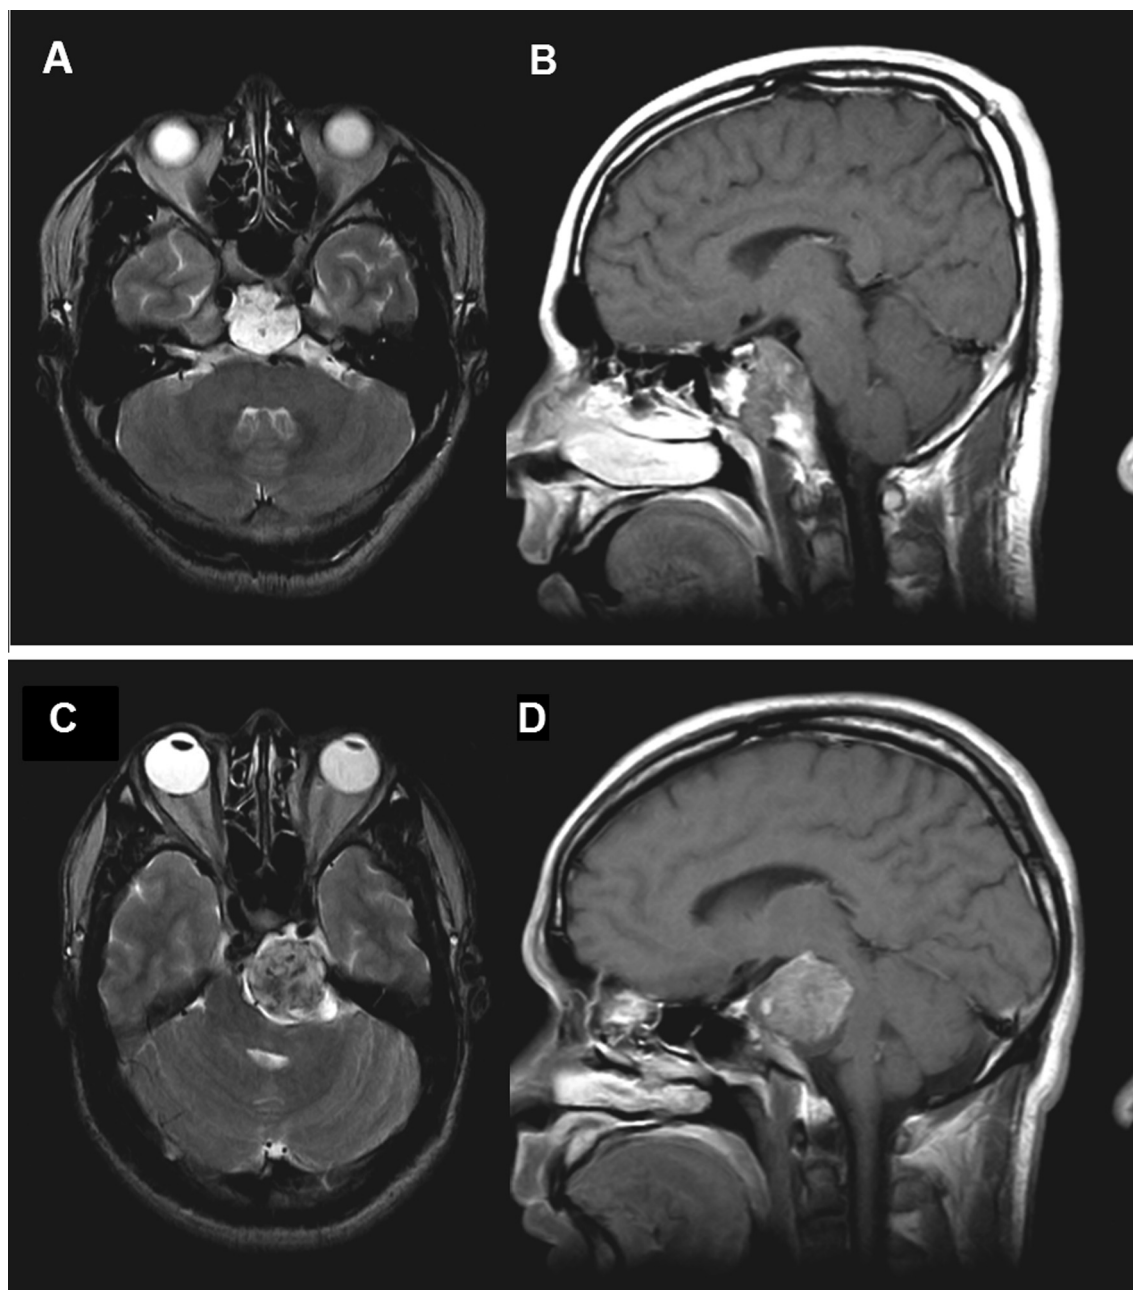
Growth pattern in clivus chordomas. (A) Axial T2-weighted and (B) sagittal T1-weighted with enhancement MRI of an endophytic clivus chordoma. (C) Axial T2-weighted and (D) sagittal T1-weighted with enhancement MRI of an exophytic clivus chordoma.
